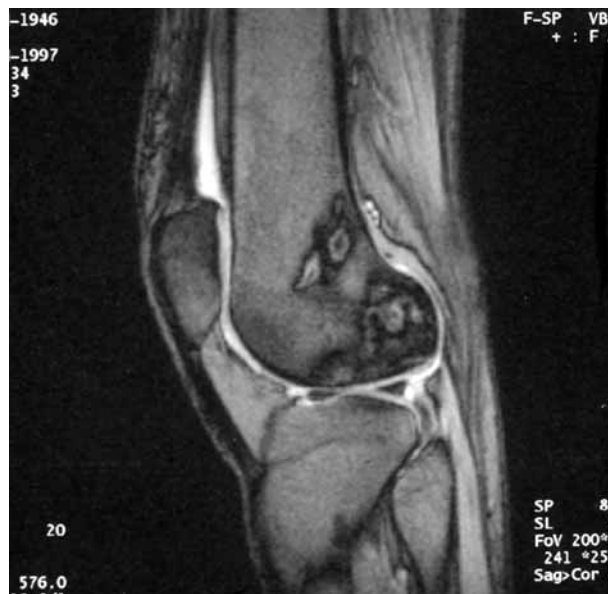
T2 weighted MRI demonstrating endosteal and epiphyseal osteonecrosis.
